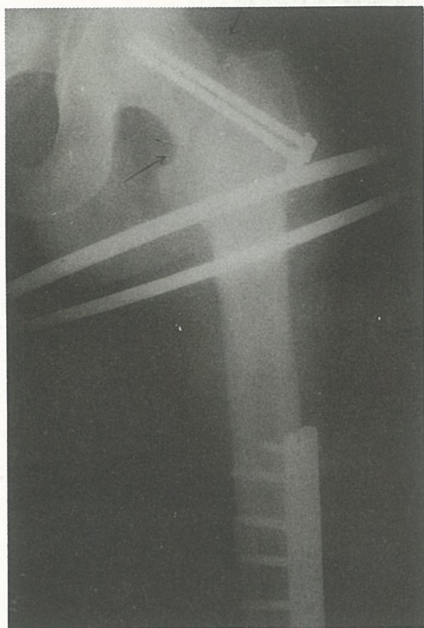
Immediate post operative x-ray of ipsilateral basal femoral neck fracture fixed by 2 cancellous screws and femoral shaft fracture fixed by A.O. Dynamic Compression Plate.
